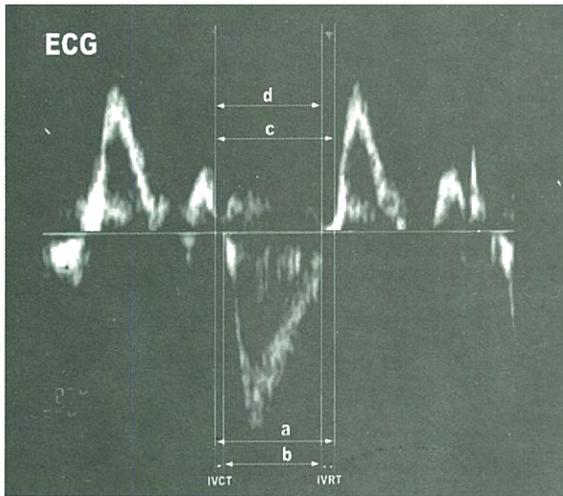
Doppler time intervals were measured from mitral inflow and left ventricular outflow velocity-time intervals
